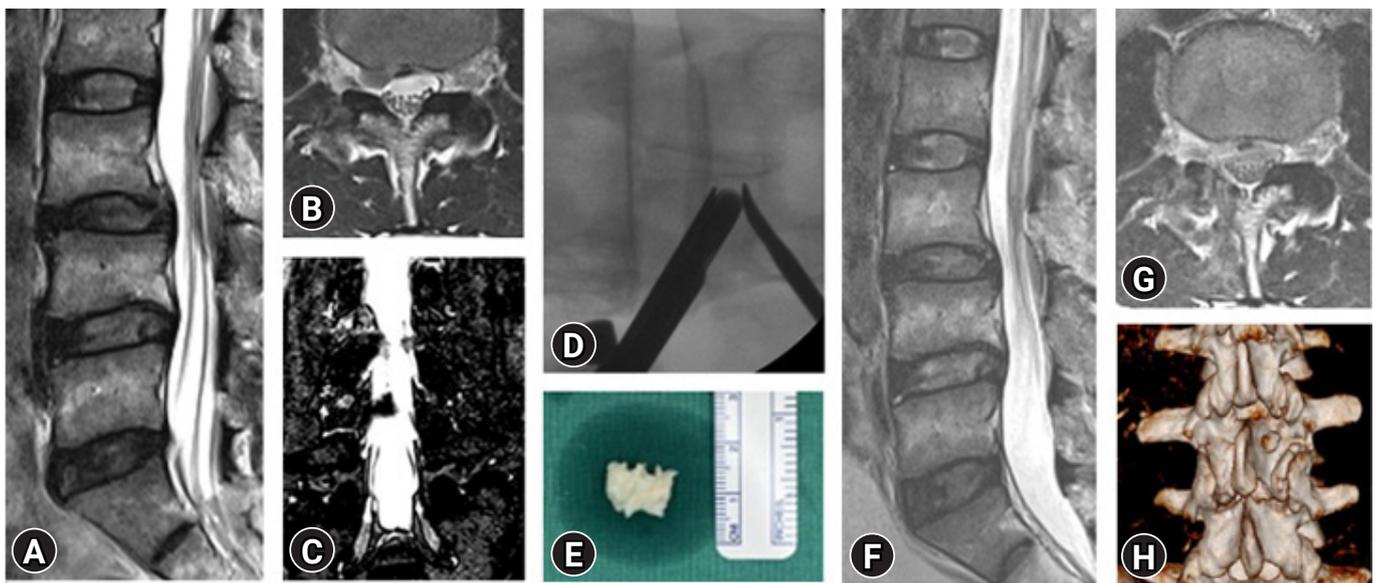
Preoperative sagittal MRI showing mild listhesis and high-grade up-migrated disc herniation at L3-4 (right). (A) Sagittal MRI, (B) axial MRI, (C) myelogram. Images during and after translaminar keyhole discectomy by UBE. (D) C-arm intraoperative image of the scope and diamond burr drilling the keyhole. (E) Fragment of disc herniation. (F) Postoperative sagittal MRI, (G) postoperative axial MRI, (H) postoperative 3D-CT.
